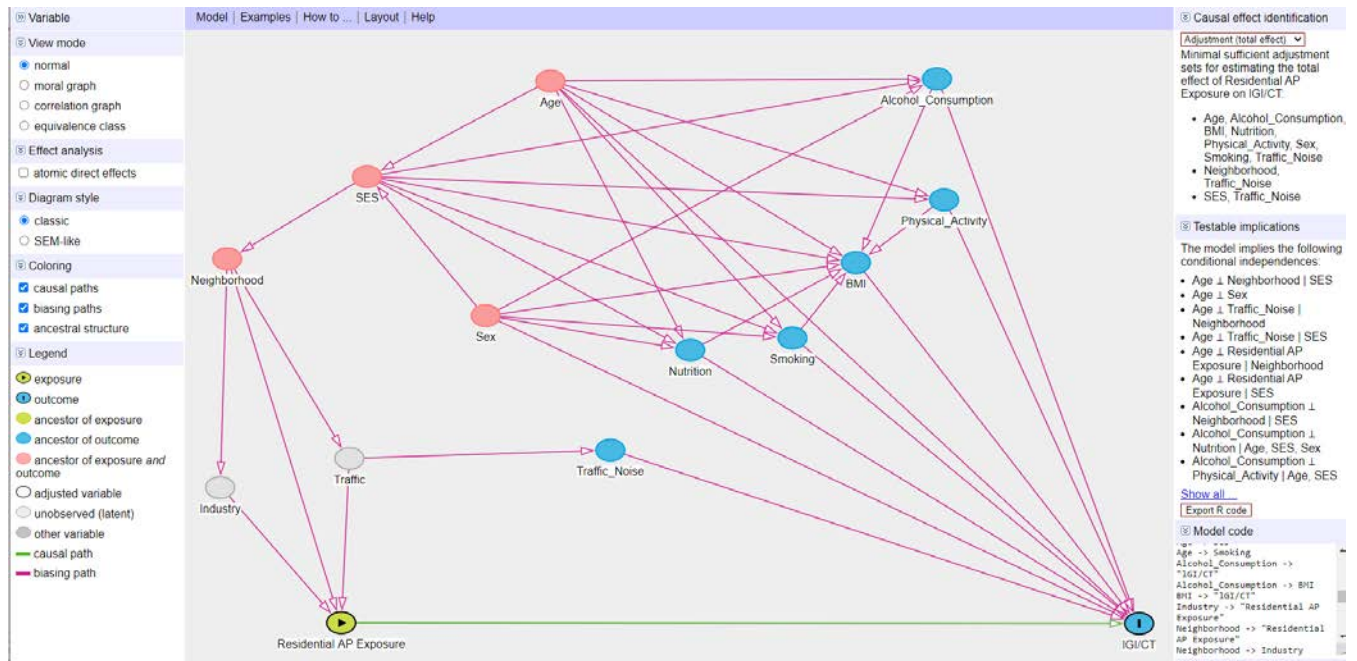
Directed acyclic graph constructed using DAGitty depicting the causal assumptions made when evaluating the associations between AP and structural measures of the Default Mode Network of the brain (IGI, CT). Minimum adjustment sets for addressing potential confounding on AP and DMN measures were: 1) Age, Alcohol Consumption, BMI, Nutrition, Physical Activity, Sex, Smoking, Traffic Noise; 2) Neighborhood, Traffic Noise; 3) individual SES, Traffic Noise.
